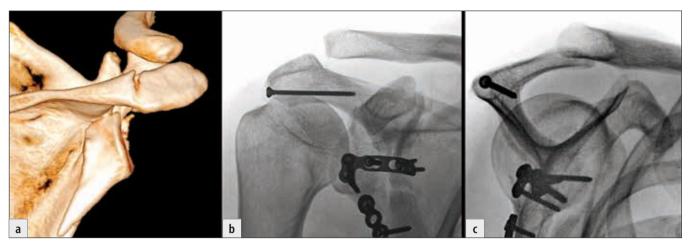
Internal fixation of a fracture of the acromial angle with a lag screw: a) fracture of the acromial angle accompanying a total glenoid fracture; b+c) post-operative radiograph. Both fractures healed in anatomical position, with fully restored function of the shoulder joint.
